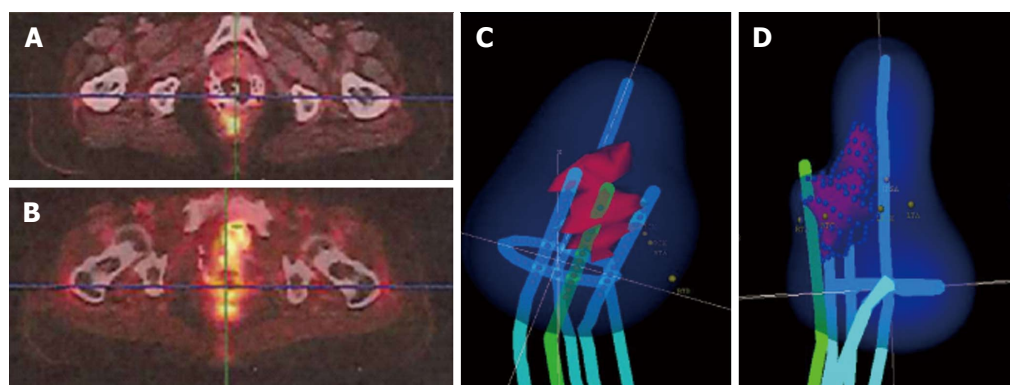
Positron emission tomography-computed tomography explore for brachytherapy planning in cervical cancers. A and B: Positron emission tomography-computed tomography with the Vienna applicator; C and D: Depiction of the 6 Gy isodose volume. The tumour in relation to the applicator is visualized within the 6 Gy volume.
